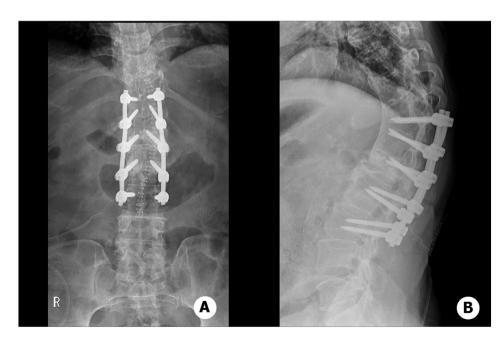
Postoperative X-rays. Posterior fixation was done in situ from T11 to L3 without decompression and angle correction.
